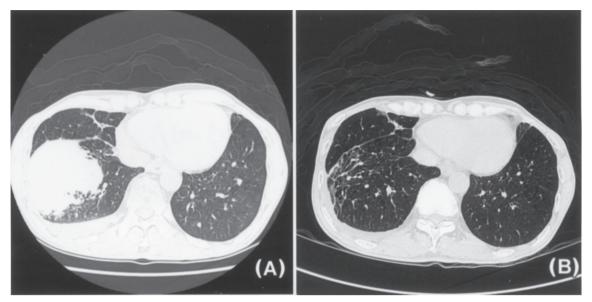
(A) High-resolution CT revealed the mass with an irregular border. (B) After treatment of more than 10 months, high-resolution CT showed near disappearance of the tumor with little fibrotic change.
